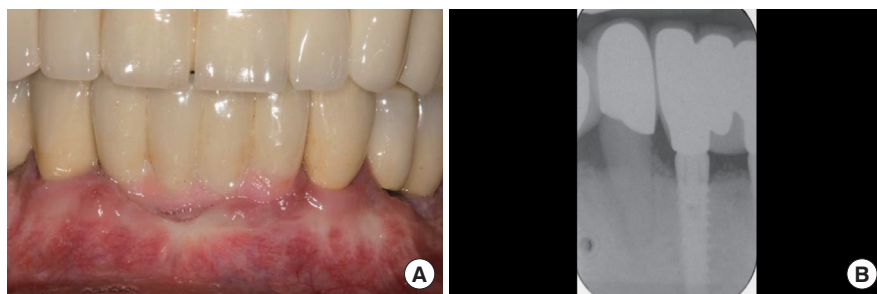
(A) Clinical presentation at 24-months after cementation of the bridge. (B) Periapical radiograph at 24-month postcementation.
